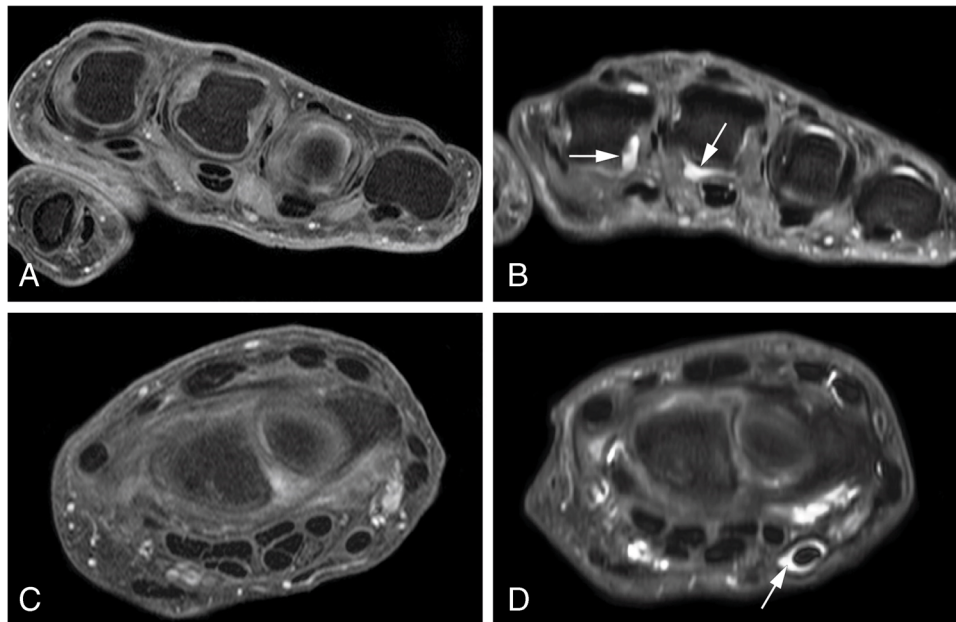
Examples of discrepancy in synovitis and tenosynovitis score between conventional axial T1-weighted TSE fat-saturated post-gadolinium images (A, C) and corresponding axial water-only mDixon images (B, D). Legend: Image A is an axial T1-weighted post-gadolinium TSE sequence with a fat-suppression image and the B the corresponding water-only axial image obtained with the T2-weighted spin-echo mDixon image of the metacarpophalangeal (MCP) joints. Joint fluid in the MCP joints results in a high signal on mDixon (indicated with white arrows) without enhancement on the post-gadolinium images. At the level of the MCP joints, no enhancing thickened synovium is seen, no (teno) synovitis is present (A). A physiologic
